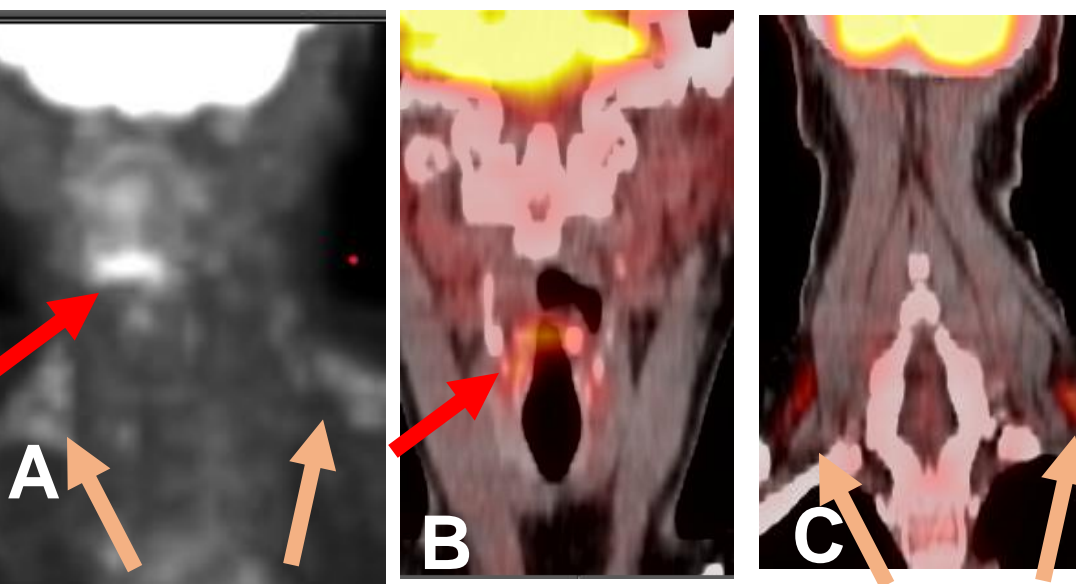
Coronal PET CT, in patient with left vocal cord palsy who was talking during the PET-CT scan with active right vocal cord movement, false positive hot on PET (red arrow), false positive brown fat also hot on PET-CT (light brown arrows!)
